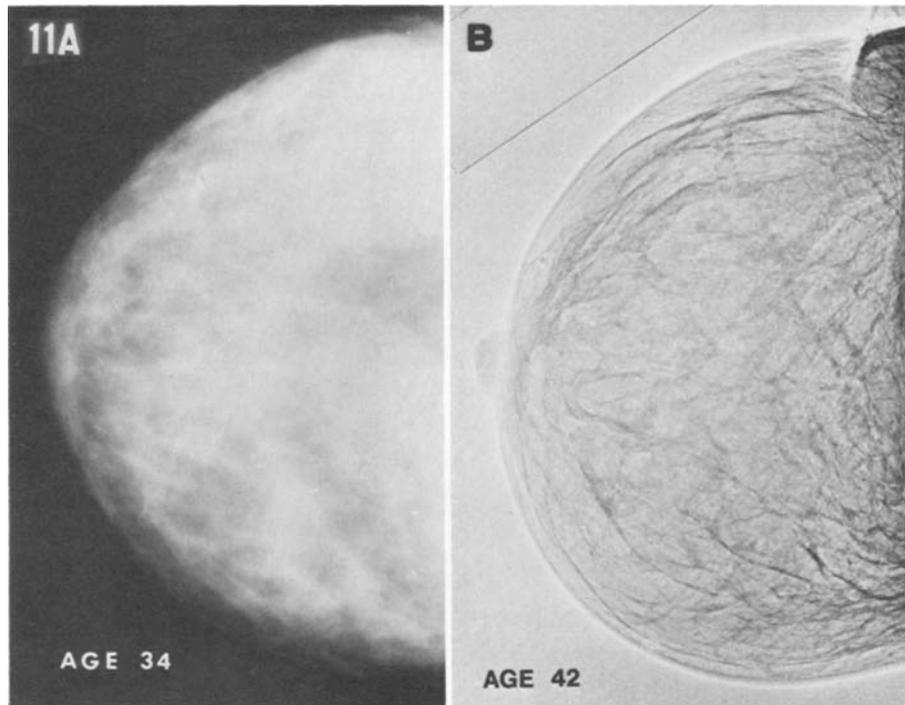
Radiographs taken 8 years apart. On the initial study there are coalescent areas of dysplasia, but also multiple ovoid and round areas of fat which would indicate a QDY classification. On the second study, most of the dysplasia has disappeared and the classification reverts to N1.
